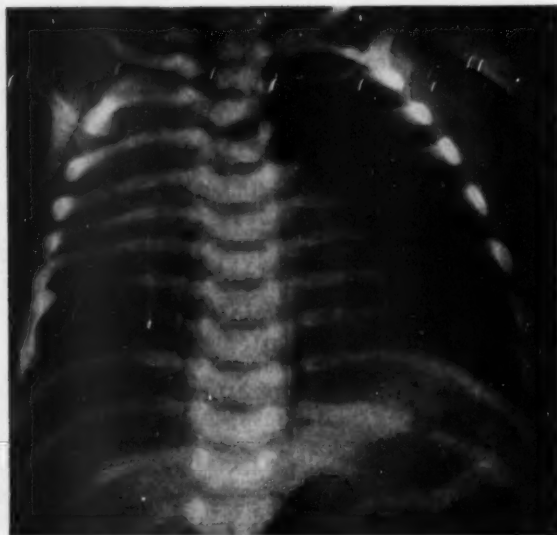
Anteroposterior conventional roentgenogram showing cardiac enlargement and displacement to the right, congenital anomalies of the spine and upper right ribs, and avascularity of the left lung.
